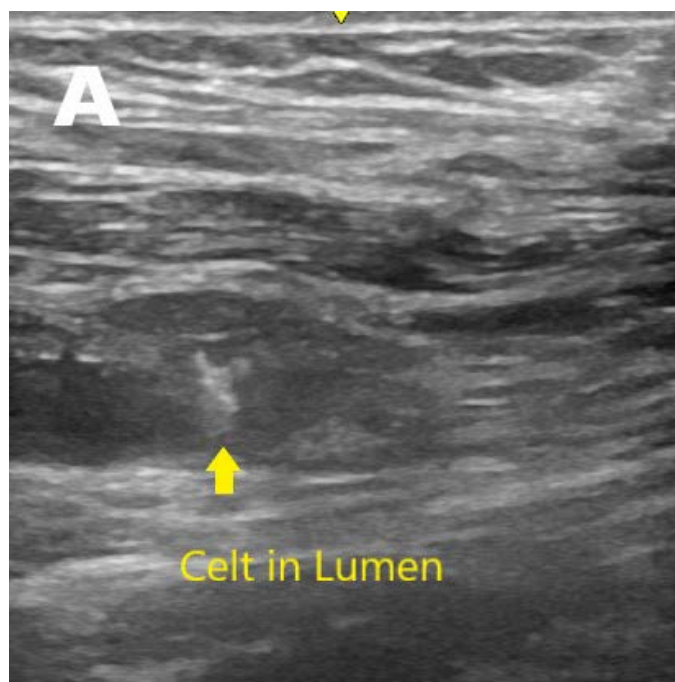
Transcutaneous ultrasound showing (A) Celt ACD vascular closure device (Veyan Medical) in lumen and (B) Celt ACD against wall.
